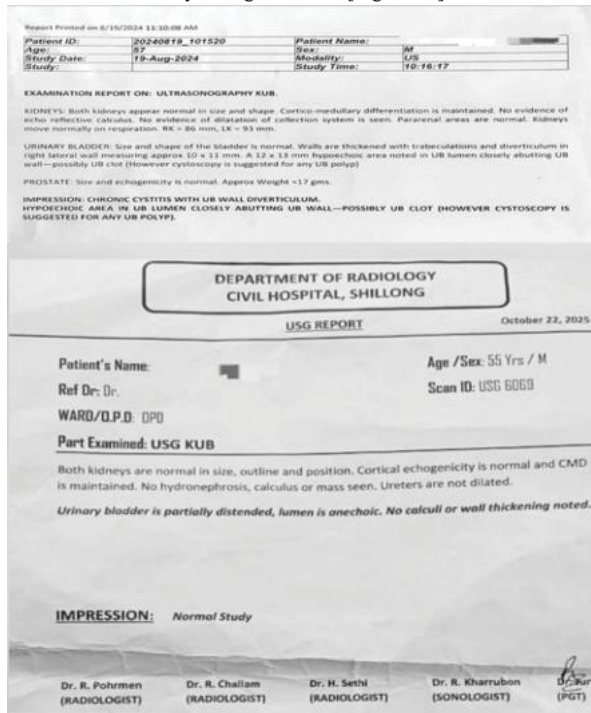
Ultrasonography Kub (Before-19/08/2024 and During Treatment-25/10/2025)
